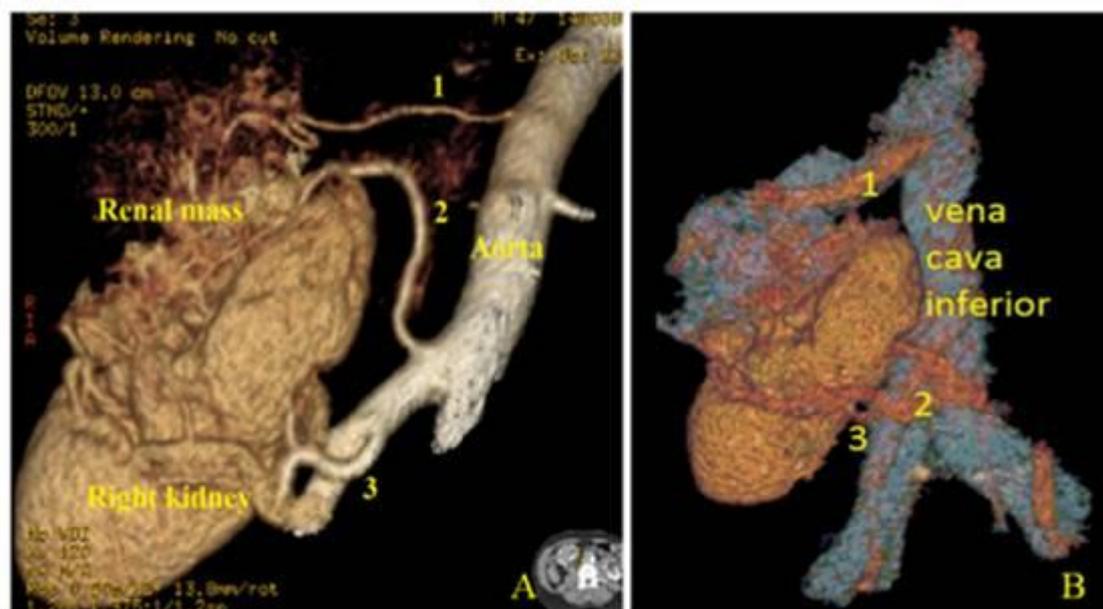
Computed tomography angiography imaging. (3D reconstruction) A. Demonstrating the association between arteries and pelvic kidney. B. Demonstrating the association between veins and pelvic kidney.
